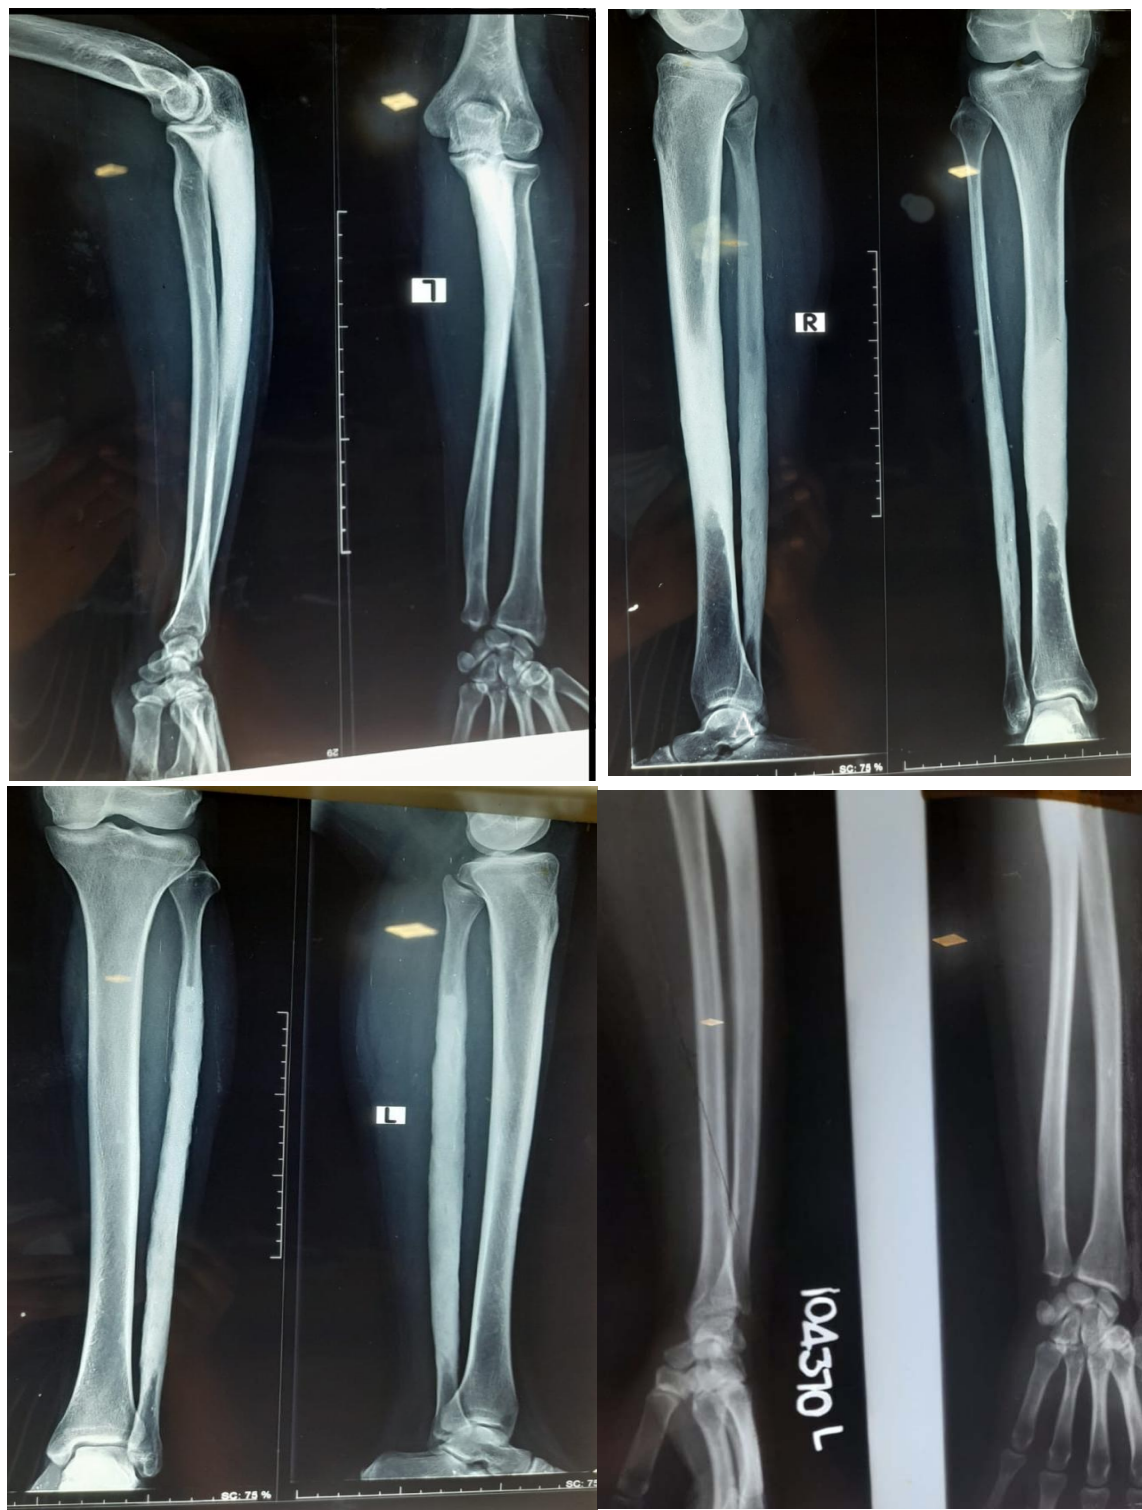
Shows radiographs of symptomatic anatomical regions show polyostotic sclerotic bony lesions involving the left proximal ulna (Figure 1A), right tibia (Figure 1B), left fibula (Figure 1C) and left proximal ulna (Figure 1D). All lesions are identical and have scalloping edges compatible with the classical description of the disorder.
